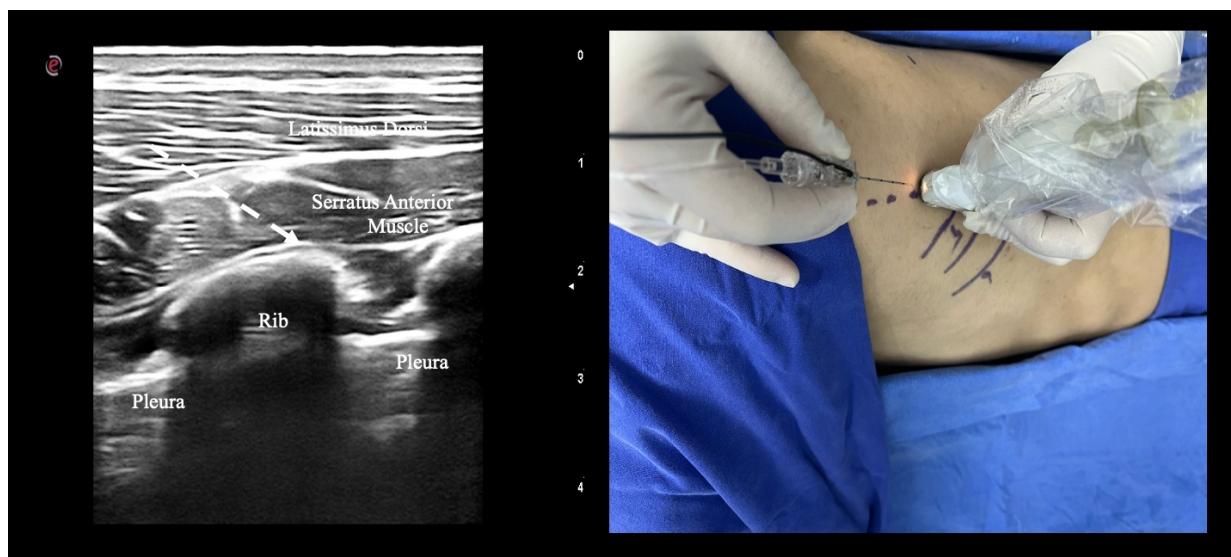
Application of the SAPB and an ultrasound image.
